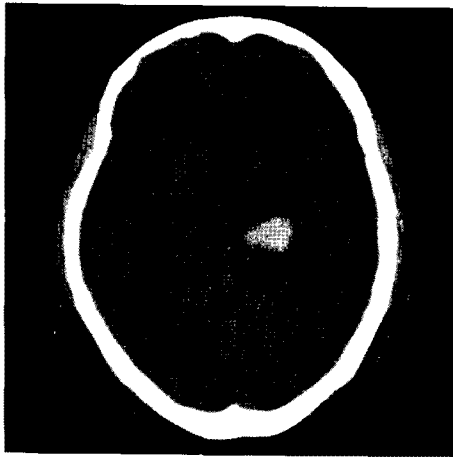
Brain CT scan 2 months before shows intracerebral hematoma at thalamus.
